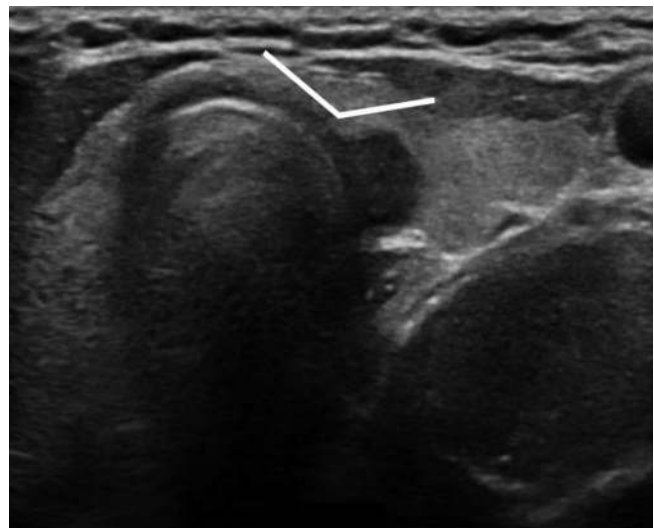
Ultrasonography feature of extrathyroidal extension of thyroid cancer to the trachea. An obtuse angle (white line) was formed between the surfaces of the trachea and thyroid cancer. Diagnosis: gross extrathyroidal extension to the tracheal wall. Adapted from Chung et al. Korean J Radiol 2020;21:1187-1195 [129].
